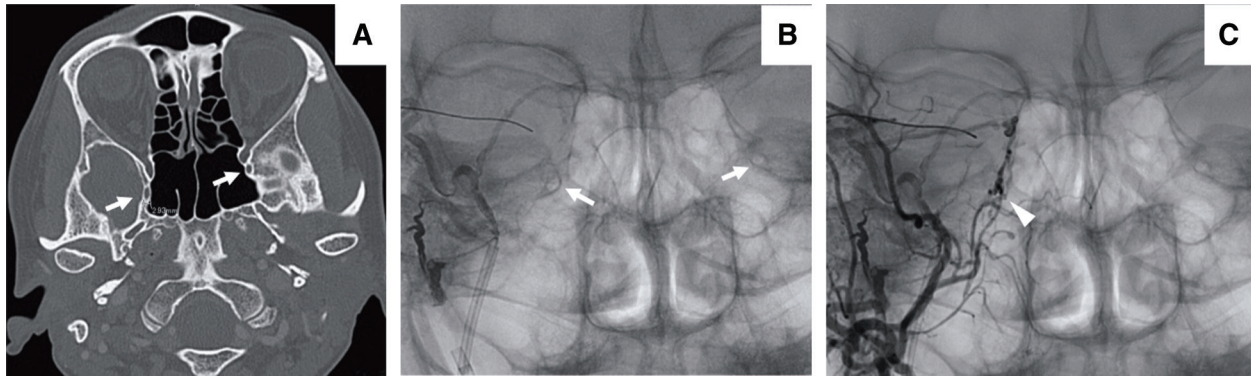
The bone window of head CT (A) and anteroposterior view of the craniogram (B) showing the bilateral foramina rotunda (white arrows). There was no significant difference in the size of either
